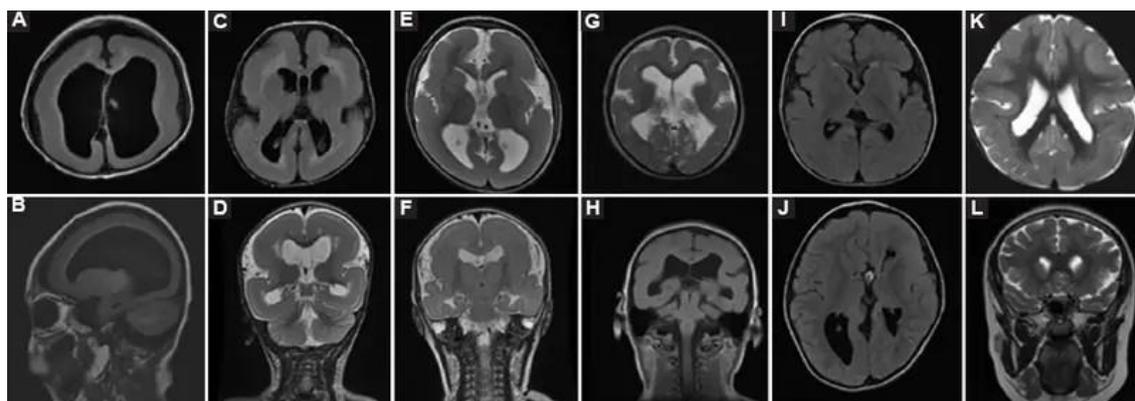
1 Brain MRI results on figs.1 A and B: diffuse agyria. C–F: diffuse agyria on the frontal and temporal poles with a few surface undulations. G-H: frontal pachygyria, parieto-occipital agyria, and mixed agyria and pachygyria. I–J: anterior pachygyria that is more severe. K: partial pachygyria posterior, more severe. L: heterotopia inside the subcortical band.^[29]
